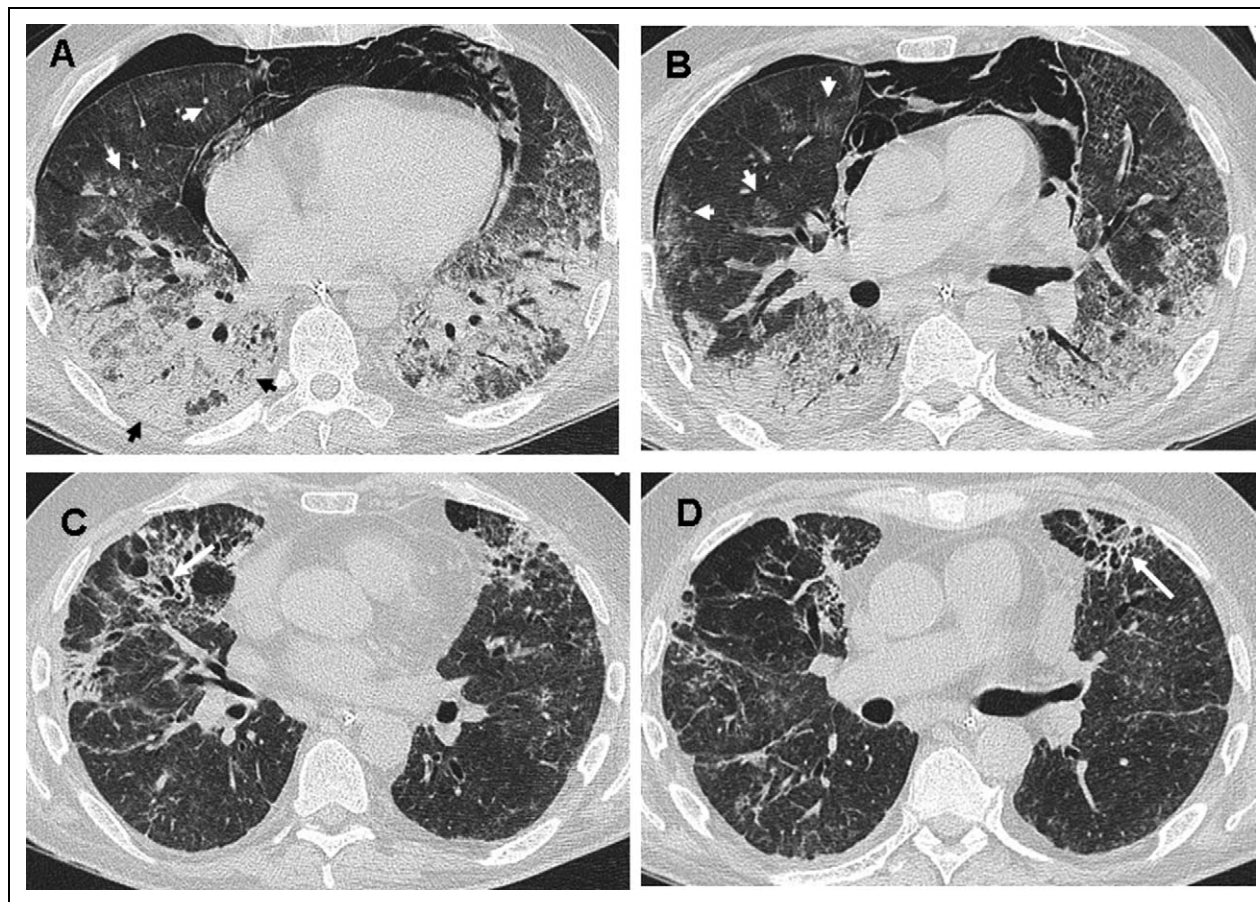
CT of a 49-year-old man with dermatomyositis with rapid onset respiratory failure: A-B: extensive consolidation (short black arrows) in the dependent lung with widespread patchy ground glass (short white arrows) anteriorly, consistent with diffuse alveolar damage (DAD)/ organizing pneumonia (OP). A right pneumothorax and a pneumomediastinum are present. C-D; after 2 months of ventilation and intensive immunosuppression, there is resolution of most of the consolidation, with residual reticulation and traction bronchiectasis (long white arrows) consistent with established fibrosis. The fibrosis is more conspicuous anteriorly, a feature of ventilator-associated damage
